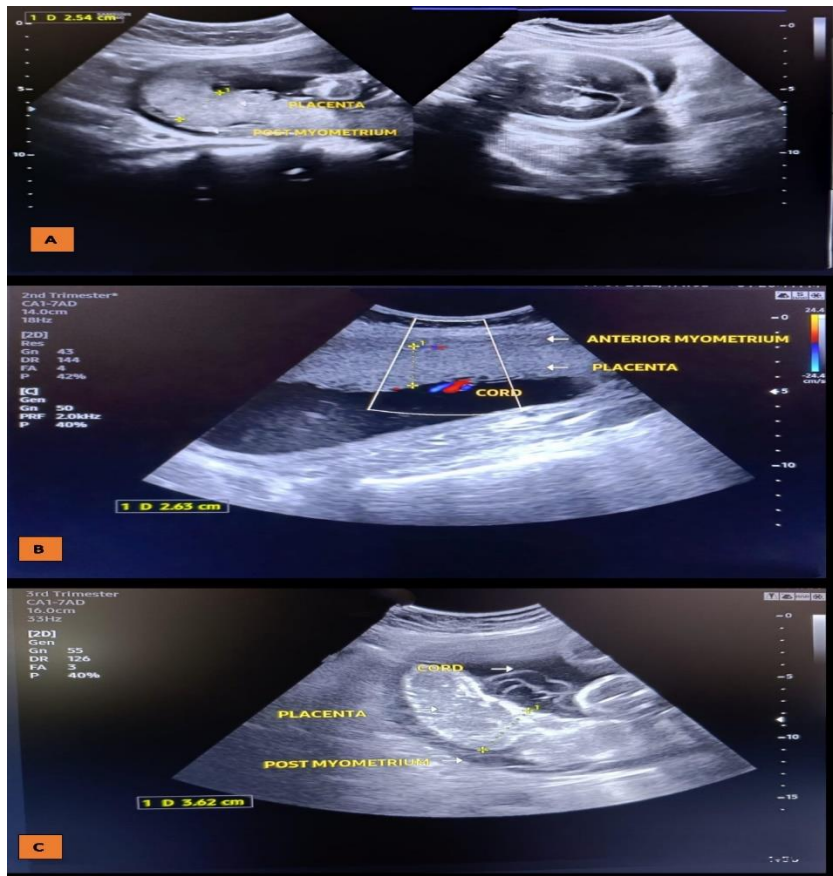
Sonogram at various gestational age. A: Sonogram showing placenta for 11-20 weeks gestational age (Placenta thickness=2.54 cm, Gestational age=19 weeks and 5 days; and weight of fetus=314 gm). B: Sonogram showing placenta for 21-30 weeks gestational age (Placenta thickness=2.63 cm, Gestational age=23 weeks and 6 days; and weight of fetus=642 gm). C: Sonogram showing placenta for 31-40 weeks gestational age (Placenta thickness=3.62 cm, Gestational age=35 weeks and 2 days; and weight of fetus=2460 gm).
